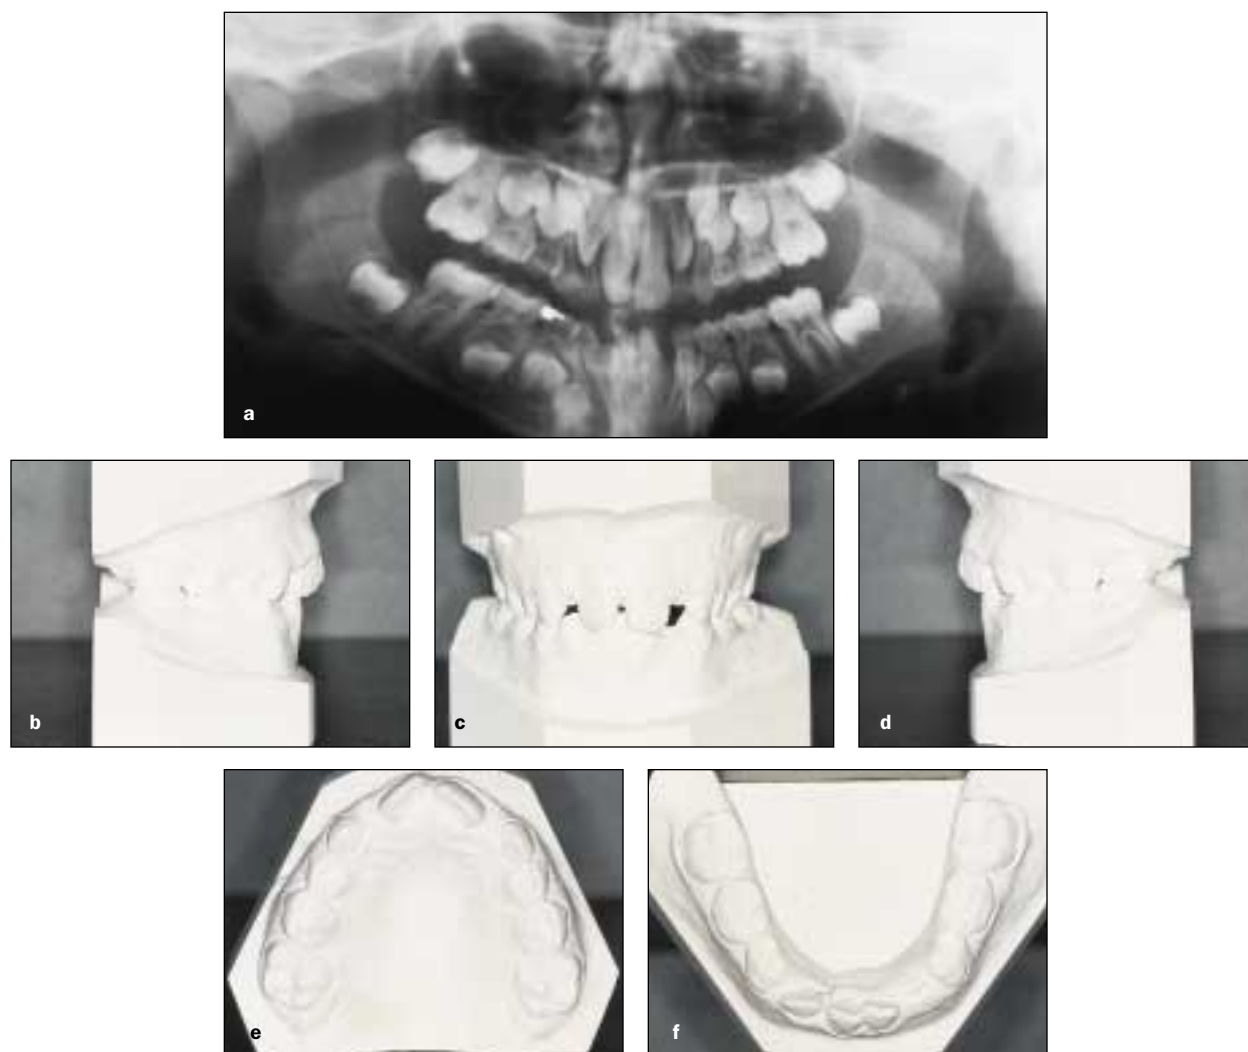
Patient at 9 years 4 months of age. (a) Panoramic radiograph. (b to f) Initial study casts.
